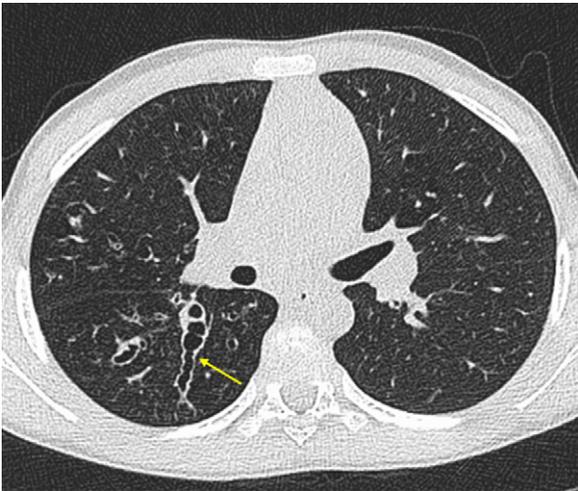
Chest CT scan demonstrating varicose bronchiectasis (arrowed) in a child with cystic fibrosis and allergic bronchopulmonary aspergillosis.
